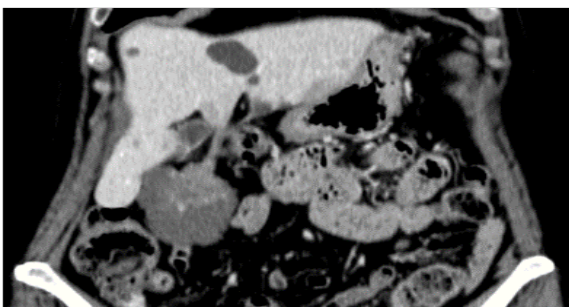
Portal phase coronal CT: Well defined pedicle connecting the mass to segment IVb of the liver (arrow).
